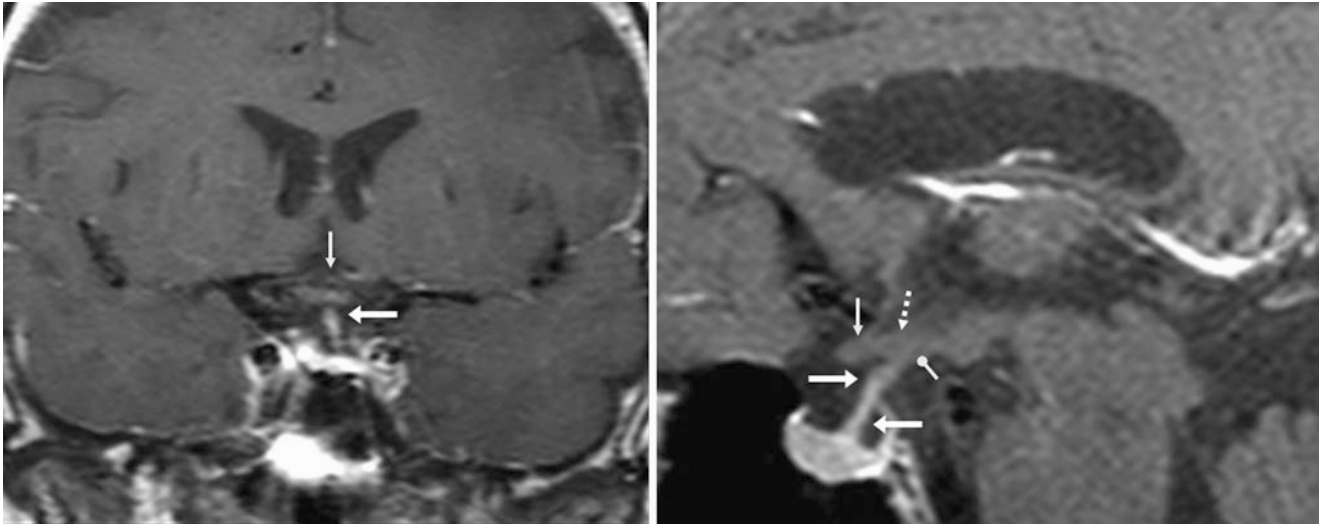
A 59-year-old female with a 3 T MRI that demonstrated normal enhancement of the pituitary infundibulum (*arrows*) relative to the nonenhancing optic chiasm (*thin arrows*). The infundibulum has a normal shift to the left on coronal delayed 5-min postcontrast T1WI (*left*).
